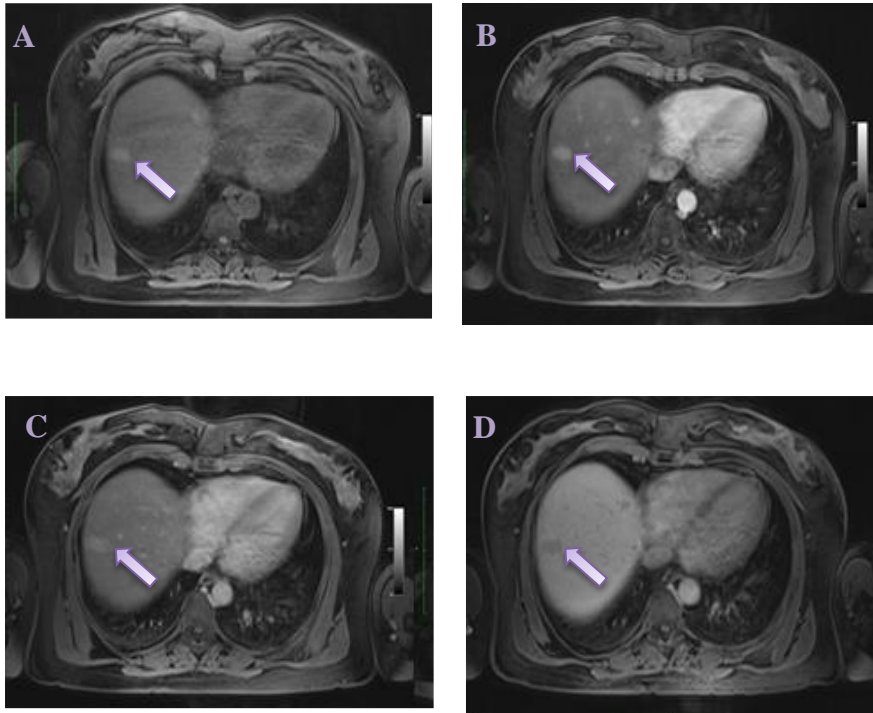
Dynamic MRI study of a bIHCA in pre-IVC (A), arterial (B), delayed (C) and hepatospecific (D) phases. The lesion appears slightly hyperintense before contrast injection and slightly enhances in the arterial phase, persisting in delayed phase. The tumor remains hypointense in the hepatospecific phase.
